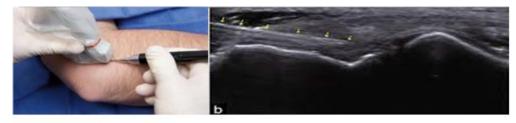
Ultrasound-guided percutaneous needle tenotomy
